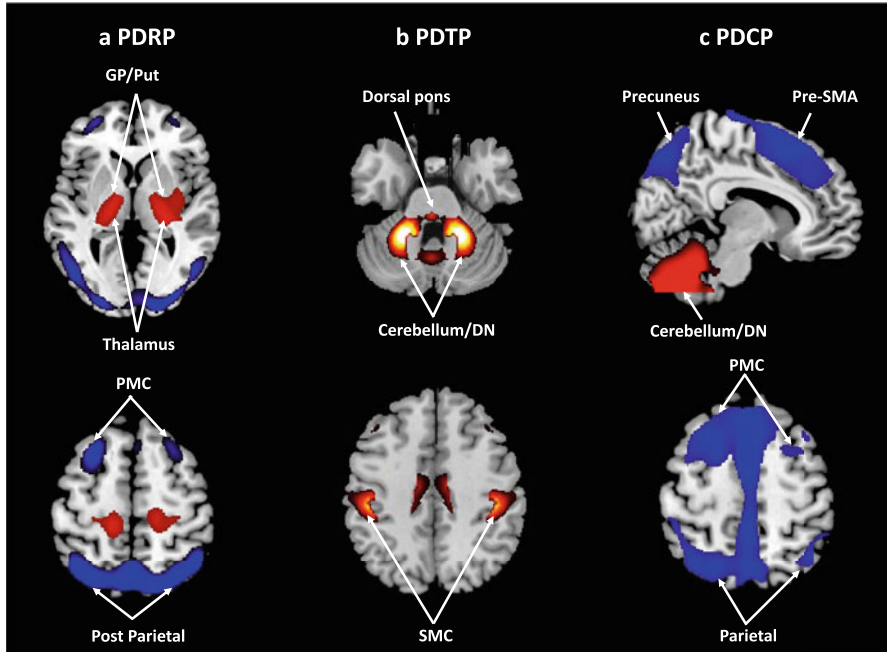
Abnormal metabolic networks in Parkinson's disease. (a) Parkinson's disease motor-related pattern (PDRP) identified by network analysis of [^{18}F]-fluorodeoxyglucose (FDG) PET scans from 33 PD patients and 33 age-matched normal volunteer subjects (Ma et al. 2007). This spatial covariance pattern is characterized by increases (red) in the metabolic activity of the putamen/globus pallidus (Put/GP), thalamus, pons, cerebellum, and sensorimotor cortex, associated with relative decreases (blue) in the lateral premotor cortex (PMC) and in parieto-occipital association regions. (Adapted from Eidelberg (2009), Copyright 2009, with permission from Elsevier). (b) PD tremor-related metabolic pattern (PDTP) identified using a within-subject network analysis of FDG PET scans from nine tremor-dominant PD patients scanned at baseline and during ventrointermediate (Vim) thalamic deep brain stimulation (DBS) (Mure et al. 2011). This pattern is characterized by covarying increases in the metabolic activity of the sensorimotor cortex (SMC), cerebellum, pons, and putamen. (Reprinted from Mure et al. (2011) Copyright 2010, with permission from Elsevier). (c) PD cognition-related metabolic pattern (PDCP) identified in a separate network analysis of FDG PET scans from 15 non-demented PD patients (Huang et al. 2007b). This spatial covariance pattern is characterized by decreases in the metabolic activity (blue) of the rostral supplementary motor area (pre-SMA), precuneus, and the posterior parietal and prefrontal regions, associated with relative increases (red) in the dentate nucleus (DN) and cerebellar cortex. (Reprinted from Eidelberg (2009), Copyright 2009, with permission from Elsevier)
